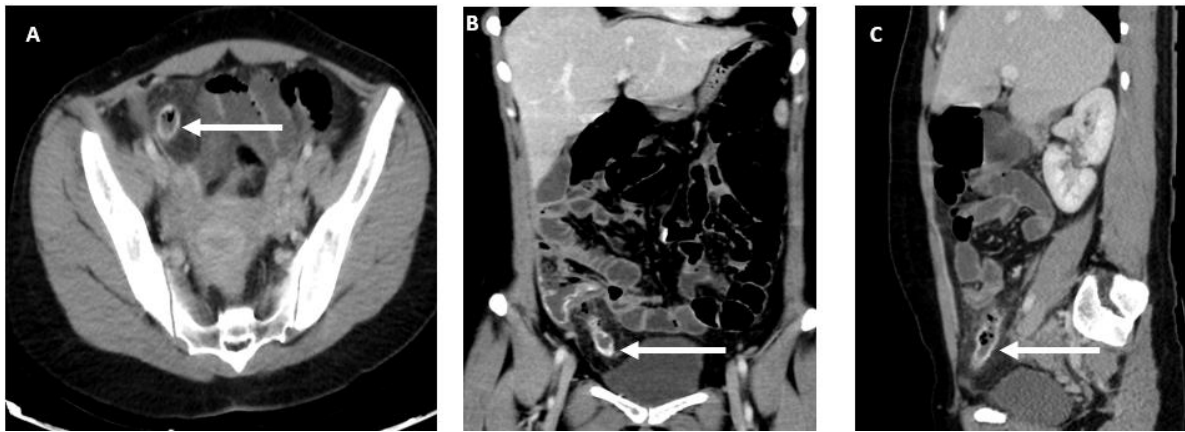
CT abdomen and pelvis in portovenous phase. (A) an axial view (B) coronal view and (C) Sagittal view. The appendix is dilated, fluid-filled with marked mural calcification.
